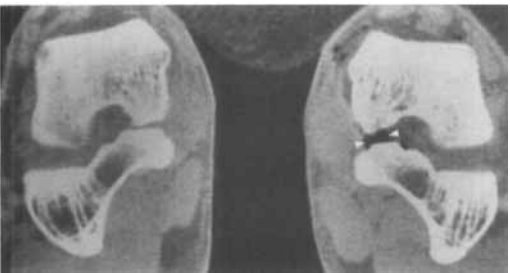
Normal negative contrast (air) CT talocalcaneonavicular arthrogram showing air (arrowheads) in the left middle facet joint space.
